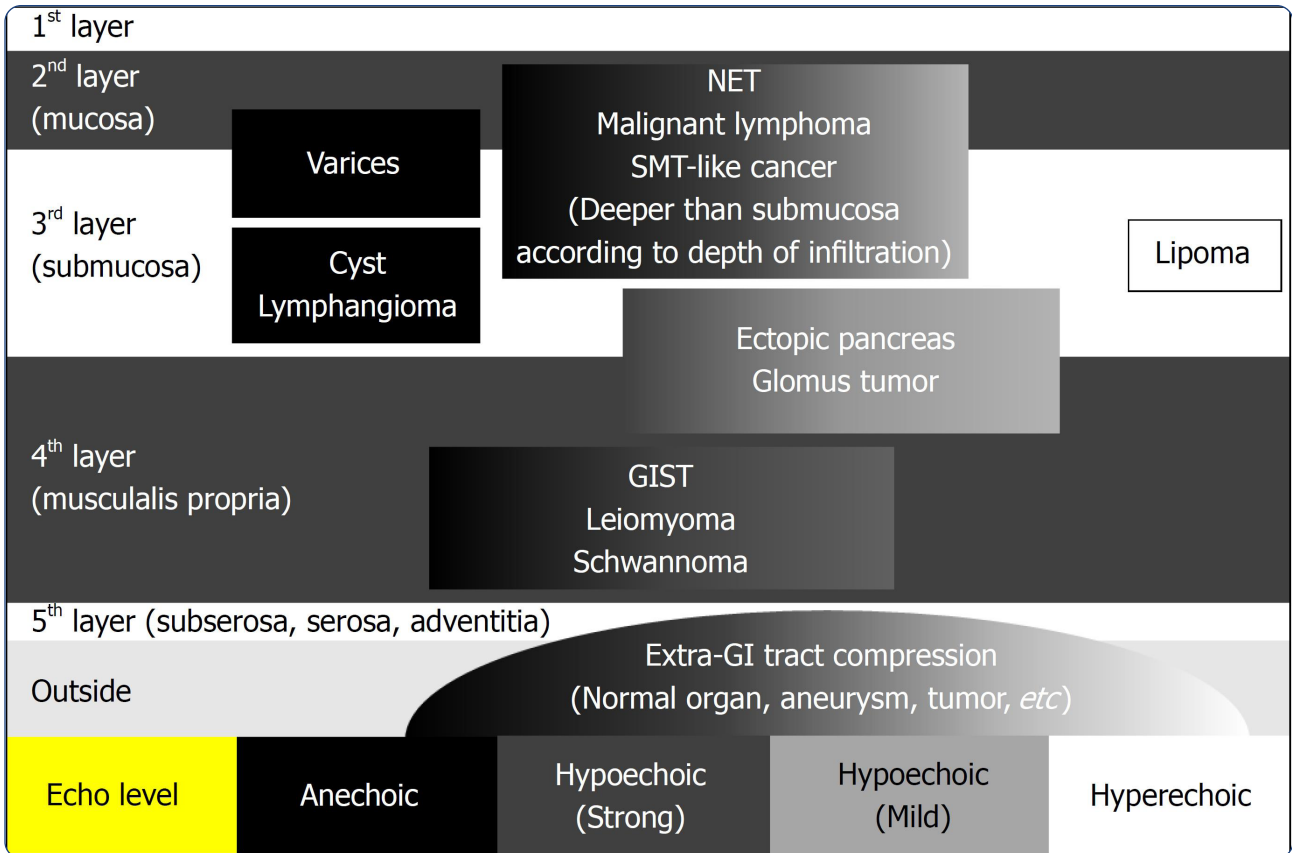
Differential diagnosis of subepithelial lesions by endoscopic ultrasound. Modified with permission from Akahoshi et al. (2018).
